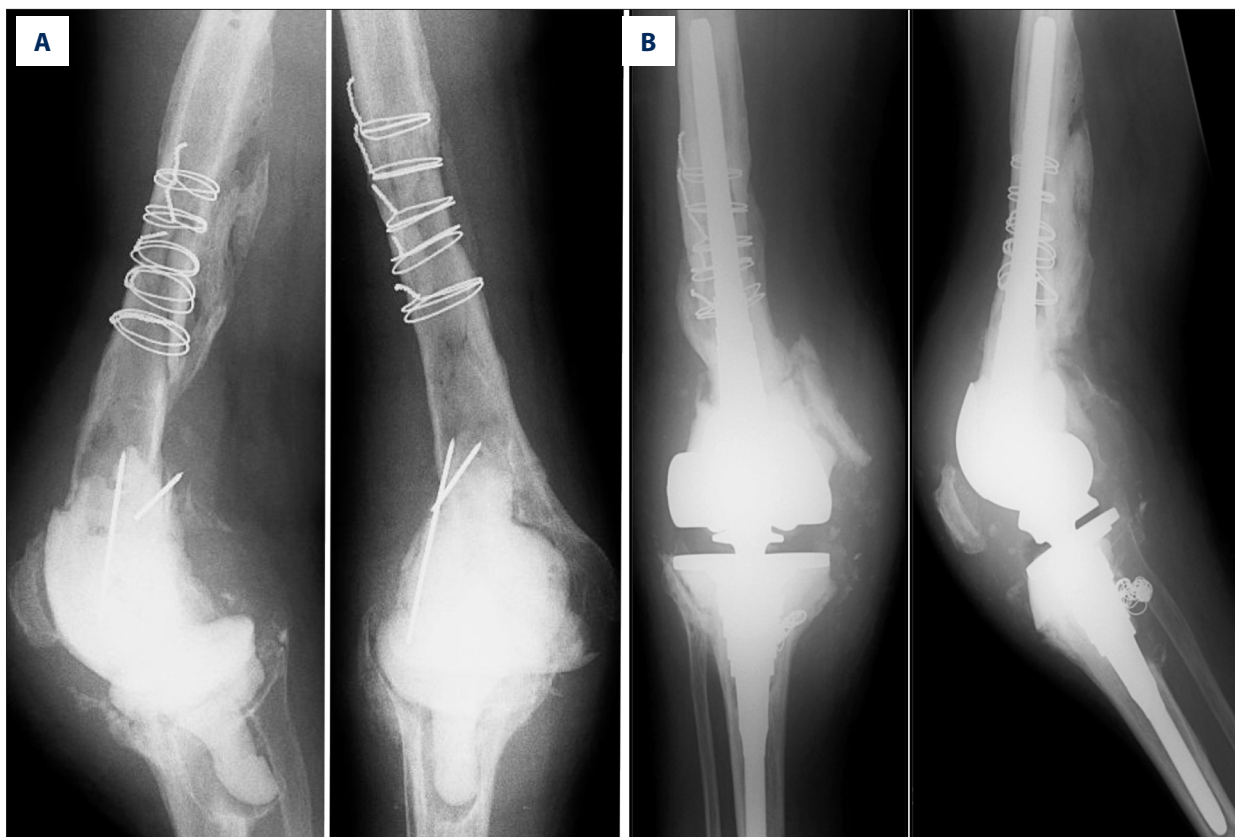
Case 4: (A) pre-operative and (B) post-operative (3.5 years) radiographs.
